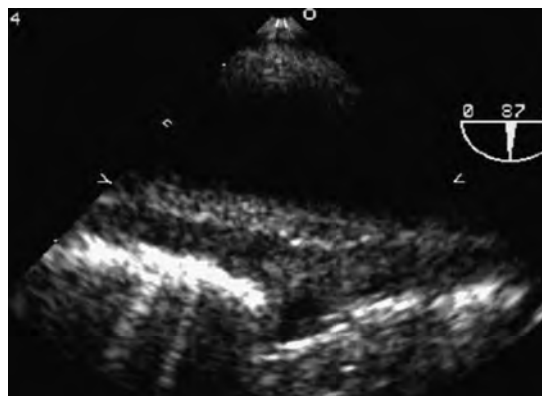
Upper esophageal transesophageal echocardiographic (TEE) long-axis view of the mid-aortic arch (at 87 degrees of rotation). There is extensive anterior intramural hematoma with a break in the aortic wall, compatible with a significant near-full thickness tear in the aortic arch. This view is diagnostic of focal traumatic transection of the aortic arch.
